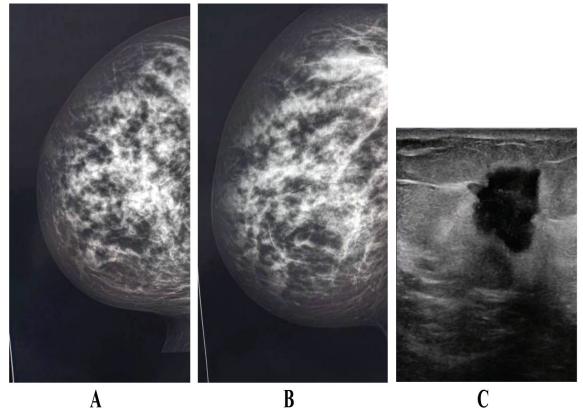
Detection of highly suspicious mass lesions in a patient with ACR-C breast density using mammography and ultrasound imaging biopsy revealed IDC-II.
